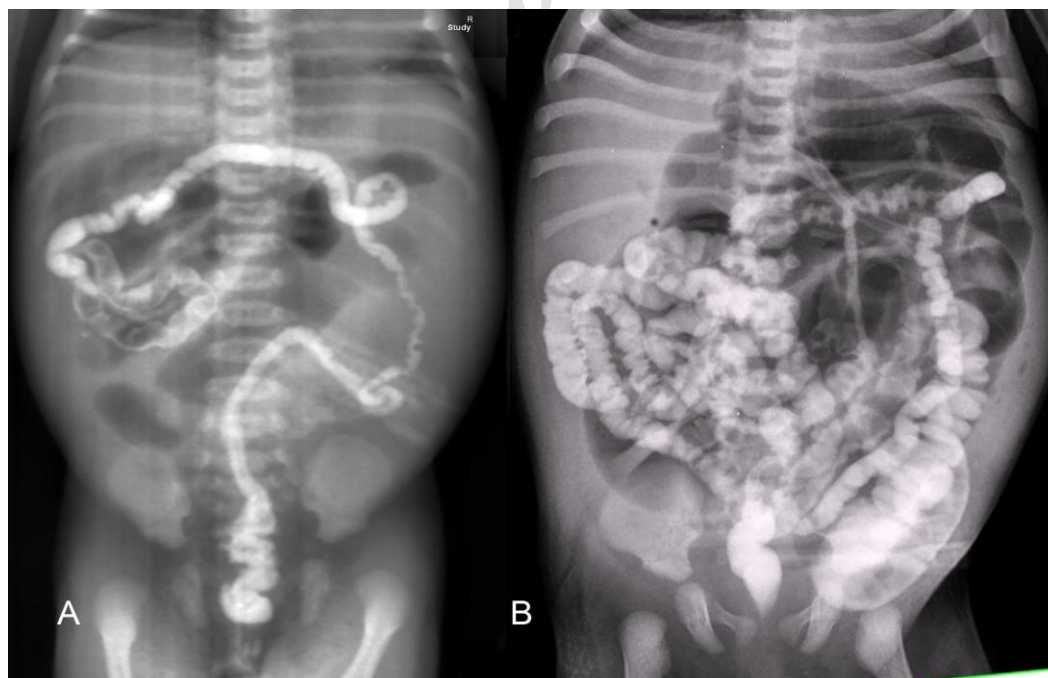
Post procedure plain abdominal X-ray (contrast study) demonstrated an unused colon (microcolon) and filling defects of inspissated meconium pellets within the terminal ileum and cecum with the arrival of contrast agent to proximal dilated loop without any sign of perforation. A) Patient with few involved loops. B) Another patient with an elongated loop of small bowel.
